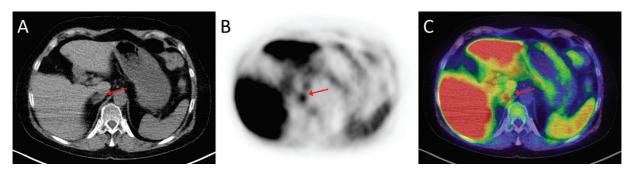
Transaxial views of the upper abdomen on computed tomography (CT) (A), positron emission tomography (PET) (B) and PET/CT fusion images (C) showing focal ¹⁸F-choline uptake in a nodular mass of the right adrenal gland (*arrows*, maximum standardized uptake value: 6.6) and a typical aspect of an adrenal adenoma on CT (radiodensity of -5 Hounsfield units).
